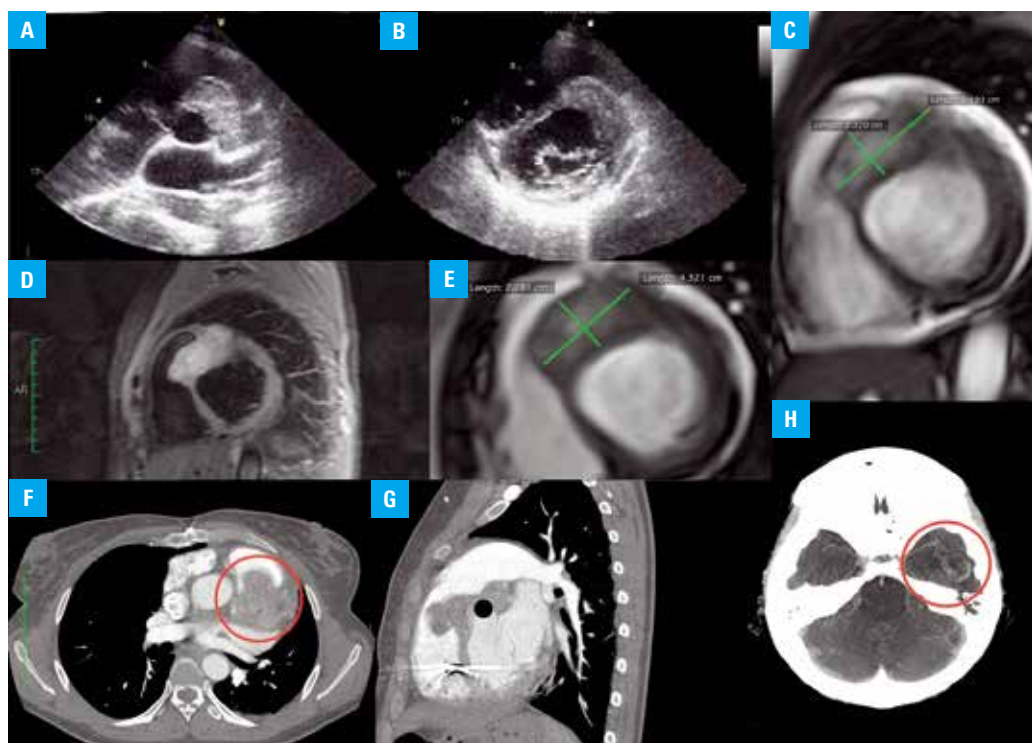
Transthoracic echocardiography, parasternal short-axis view (aortic valve level), a tumor results in the right ventricular outflow tract obstruction; B – transthoracic echocardiography, parasternal short-axis view (mitral valve level), tumor in the interventricular septum; C – cardiac magnetic resonance imaging, T_2 -weighted image of the primary cardiac tumor: the first examination (short-axis view); D – cardiac magnetic resonance imaging, T_2 -weighted triple inversion recovery TSE (Black-Blood turboSTIR); E – cardiac magnetic resonance imaging, T_2 -weighted image of the tumor 4 months later (short-axis view); F – chest computed tomography (CT) 5 minutes after contrast infusion (transversal axis); G – chest CT 5 minutes after contrast infusion (sagittal axis); H – brain CT revealing a large tumor (30 × 25 × 25 mm) in the temporal lobe (one of the brain metastases)
